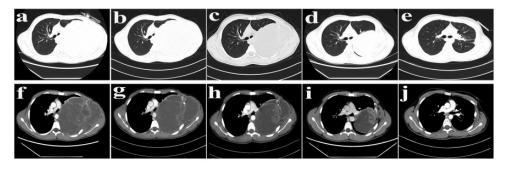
Computed tomography scan of the chest conducted at West China Hospital, Sichuan University, showing: (a and f) the tumour before chemotherapy; (b and g) the tumour after the second cycle of chemotherapy; (c and h) the tumour after the fifth cycle of chemotherapy; (d and i) the tumour after all cycles of conversion chemotherapy; and (e and j) disappearance of the cancer following surgery. Panel a–e shows the lung windows, and f–j shows the mediastinal windows.
